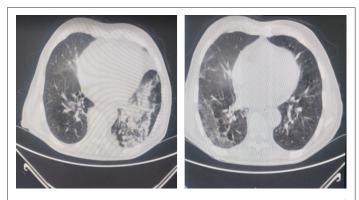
Chest CT scan showing ground-glass attenuation in the left lung, compatible with COVID-19. At hospital admission, the patient had a C-reactive protein of 20 mg/L, with a limit of 0.5 mg/L. After 5 days of hospitalization, he was discharged with a C-reactive protein of 3.0 mg/L.
